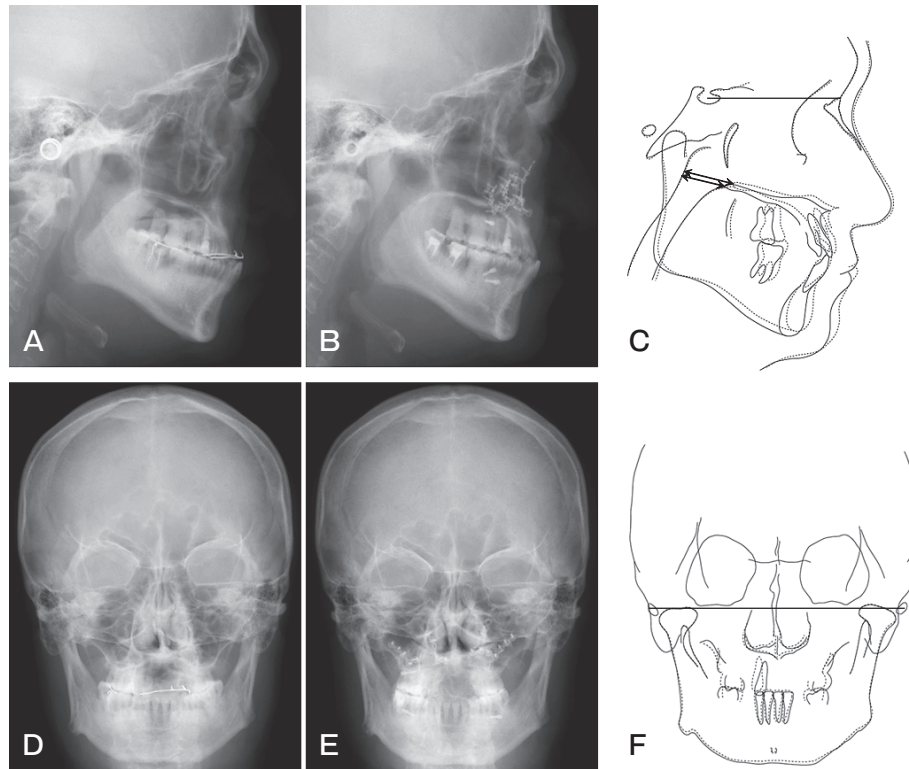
Cephalometric radiographs. A, D, Pretreatment; B, E, Post-treatment; C, F, Superimposed cephalometric tracings show the changes from the pretreatment (solid line) to post-treatment (dotted line) stages on the sella-nasion plane at the sella (C) and on the zygion-zygion plane at the crista galli (F). Left/right arrows show the NPD (nasopharyngeal depth): the distance from PP1 to PNS (C).
